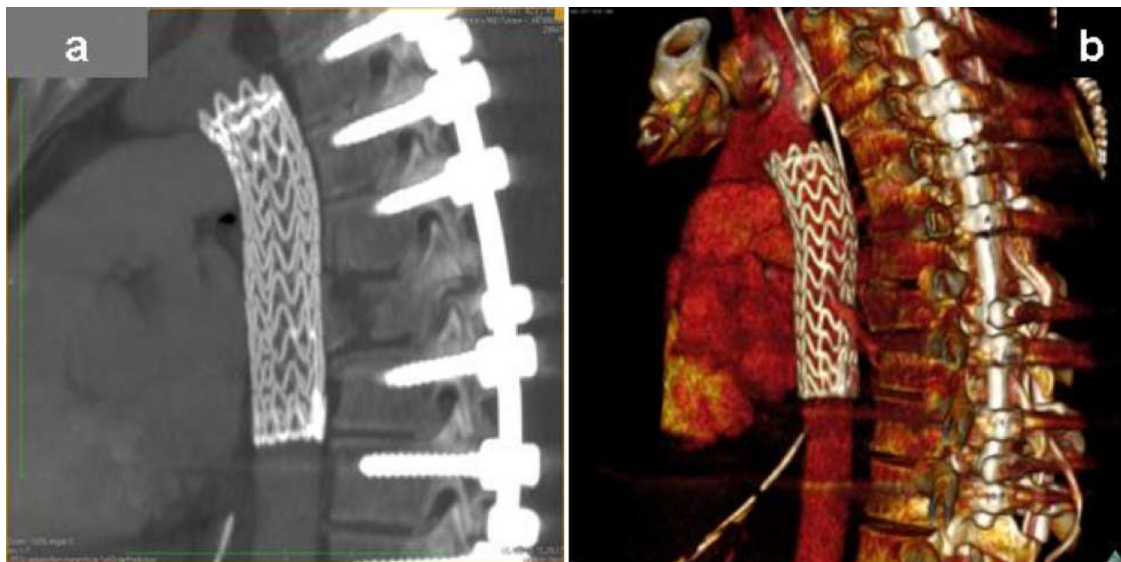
Post-treatment CT-angiography: sagittal (a) and 3-D reconstruction views (b): aortic stent-graft in place with posterior instrumentation of the spine.
